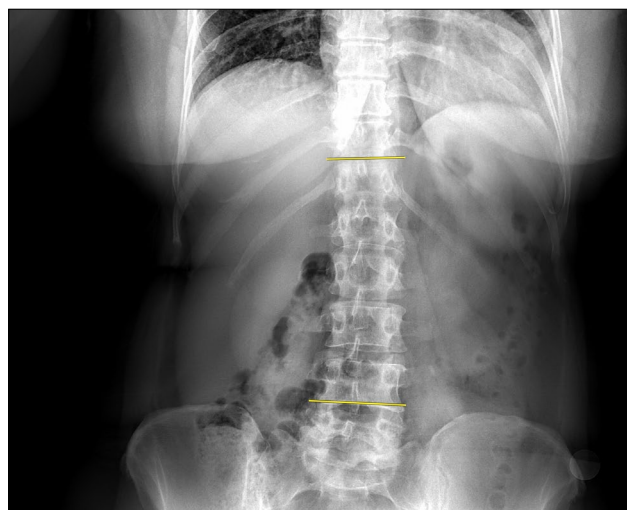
Frontal whole spine radiograph. The Cobb angle (yellow lines) was measured at 4° .
